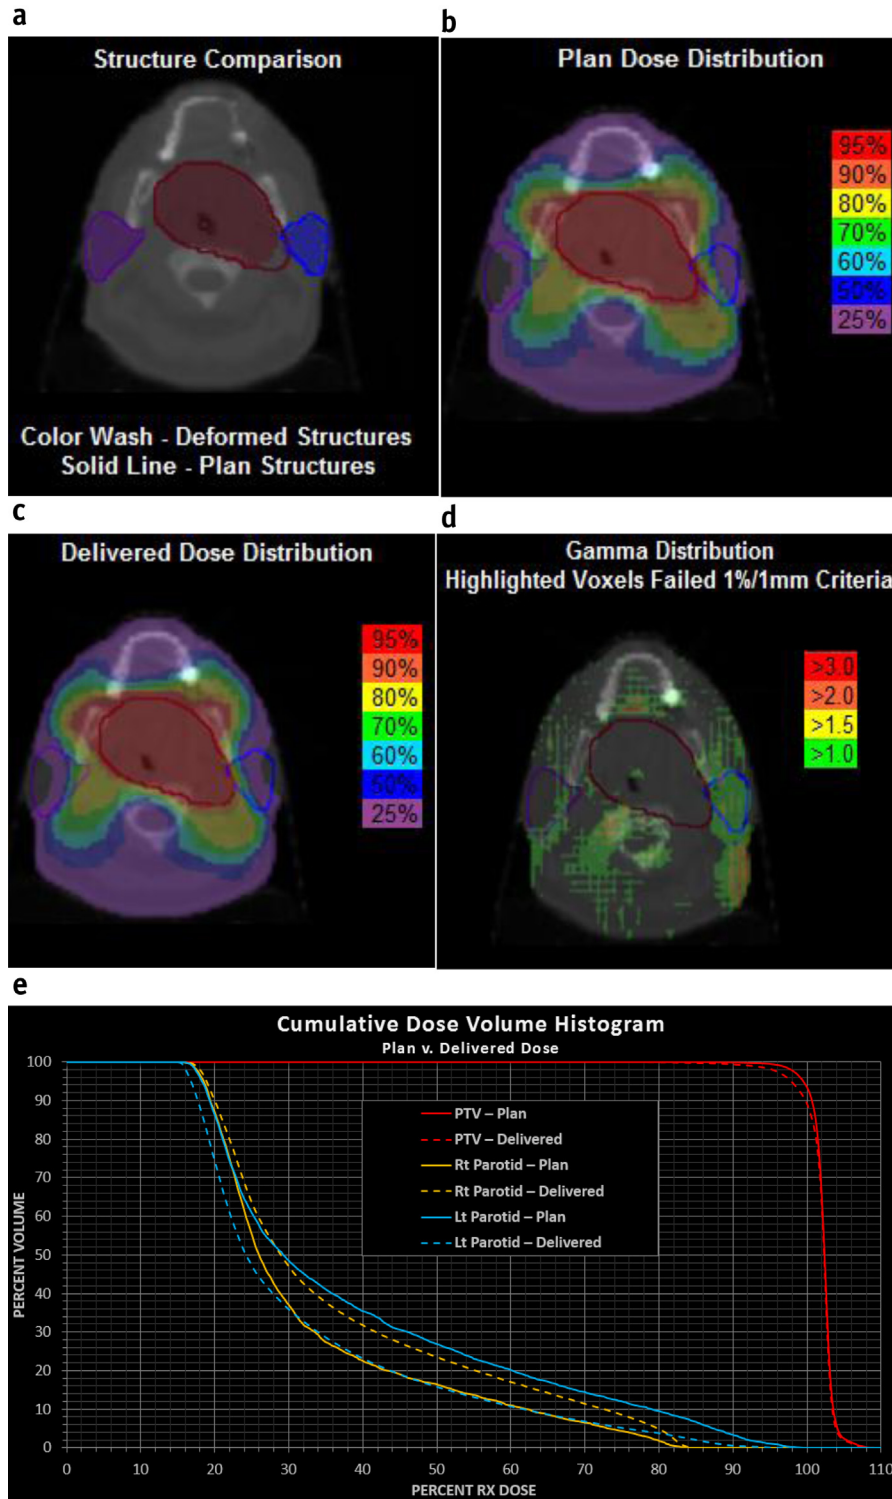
(a) Planned and deformed structures on a weekly kVCT; (b) planned dose distributions; (c) delivered dose distribution; (d) calculated gamma distribution (gamma >1) overlaid on the weekly kVCT; (e) comparison of the planned to delivered DVHs for the PTV1 and parotid glands. DVH = dose-volume histogram; kVCT = kilovoltage computed tomography; Lt = left; PTV = planning tumor volume; Rt = right.
